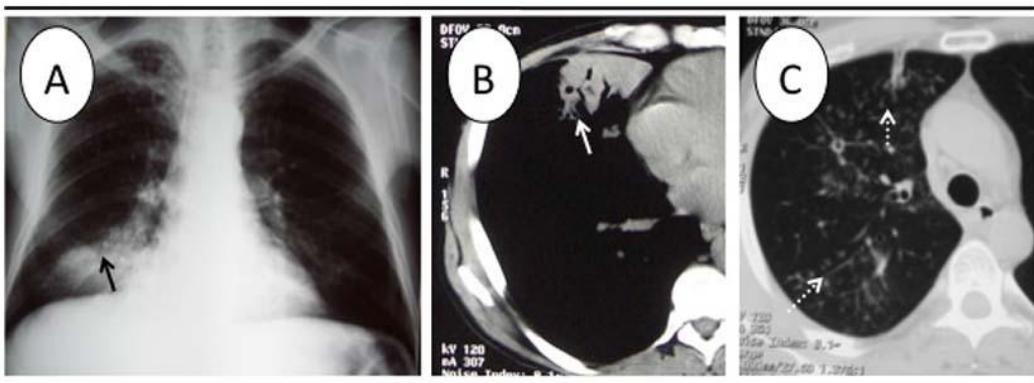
35 year old man with alveolar pattern mass in middle lobe (solid arrows), CT data added occupation of small airways (discontinuous arrows), suggesting a tuberculous etiology which was later confirmed.
